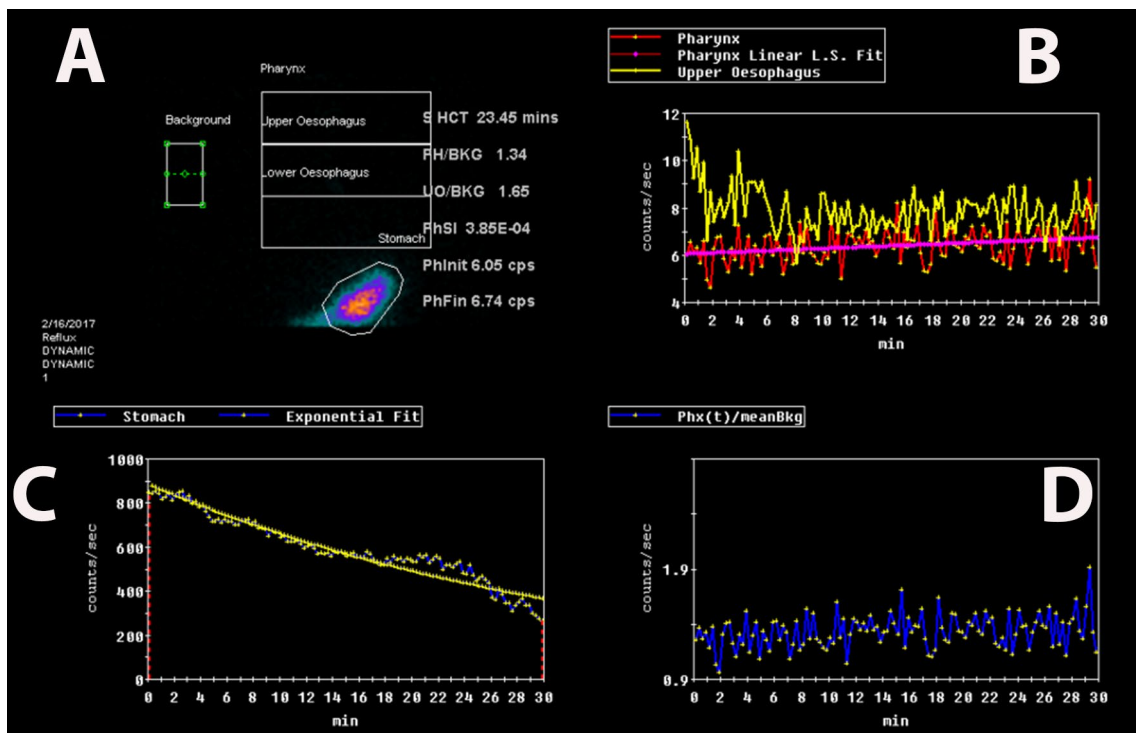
Typical graphical analysis of the scintigraphic study showing the markings of the regions of interest for the pharynx, esophagus, stomach, and background in the top left panel (a). b Analysis of the time-activity curves for the pharynx (pink/red) and upper esophagus (yellow). A rising curve is apparent for the pharynx (purple line
